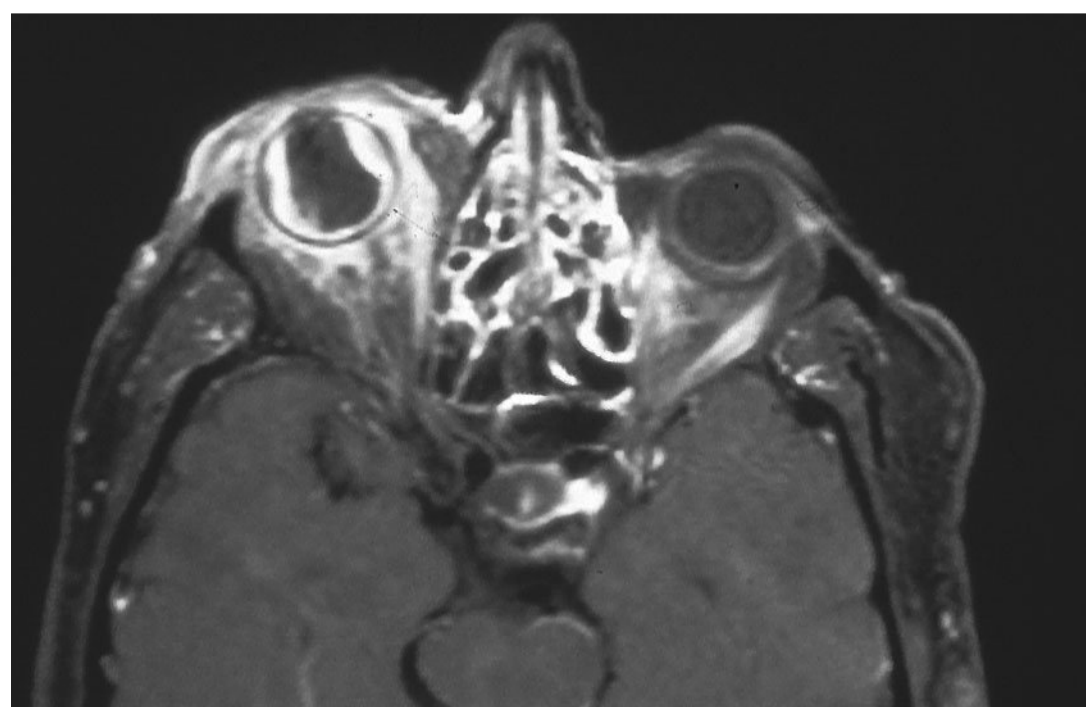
Post-gadolinium magnetic resonance imaging shows diffuse thickening of the sclera and episcleral tissues as well as the presence of choroidal thickening.
